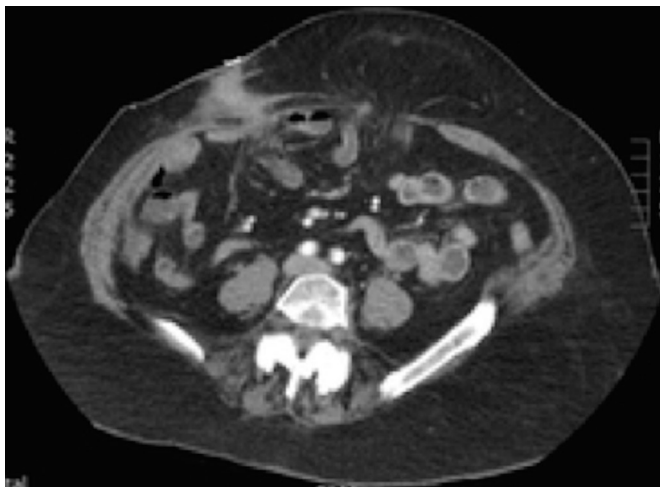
Transverse CT image showing the enterocutaneous fistula in the right iliac fossa and the recurrent umbilical hernia in the midline.
